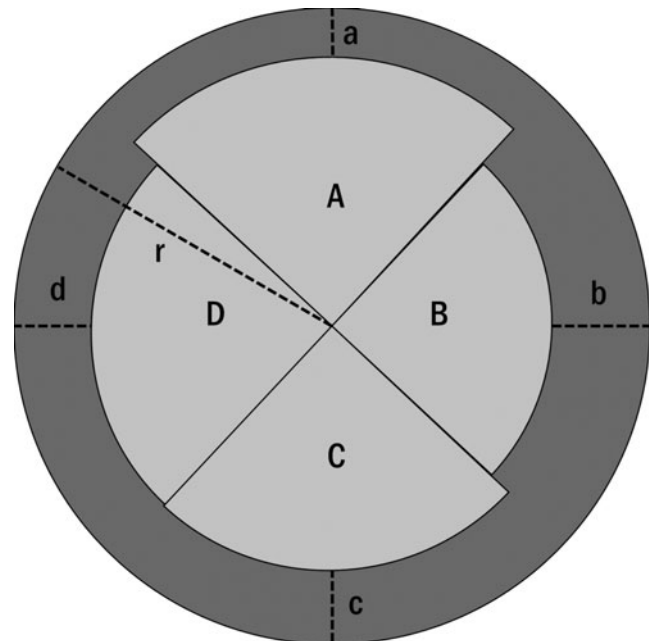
Ultrasonographic measurement at 10 cm above and below elbow crease (a, superior, b, medial, c, inferior, d, lateral direction) is shown. The areas of A, B, C, and D are imaginary inner areas. Δ CSA is calculated by a designed formula described above. Δ CSA, Δ cross-sectional area.
